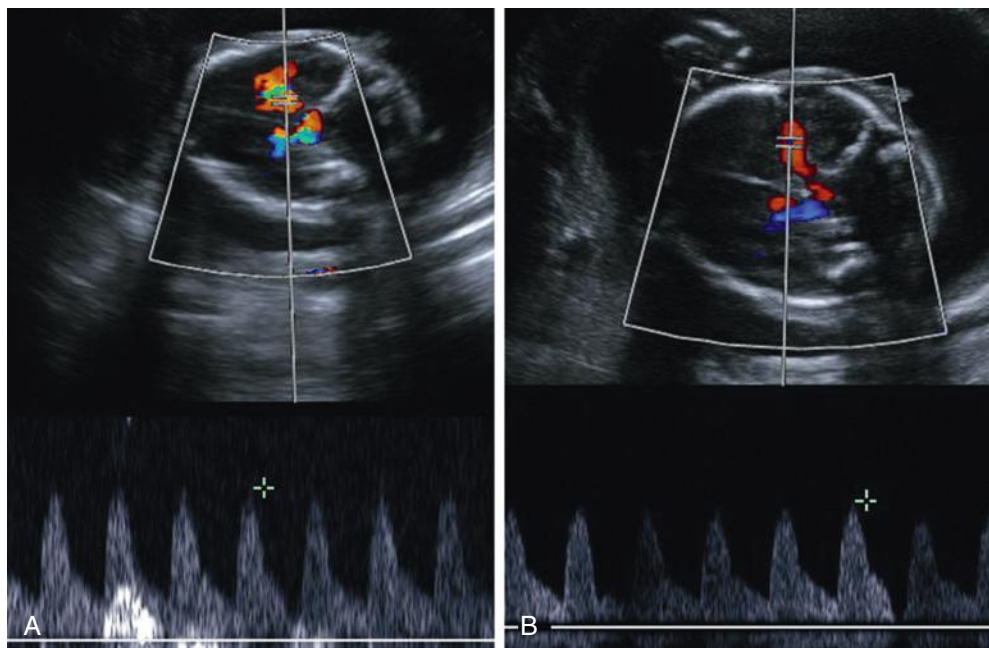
Color and spectral Doppler imaging of fetal middle cerebral artery (MCA) with measurement of peak systolic velocity (PSV). A, PSV measured 39 cm/second. Because of suboptimal technique with high gain and low scale settings and incorrect placement of sample gate, the peak velocity was erroneously undermeasured. B, With improved technique, including adjustments in gain, scale, angle of insonation, and sample gate placement, true peak velocity in the MCA was obtained and found to be 46.5 cm/second.
